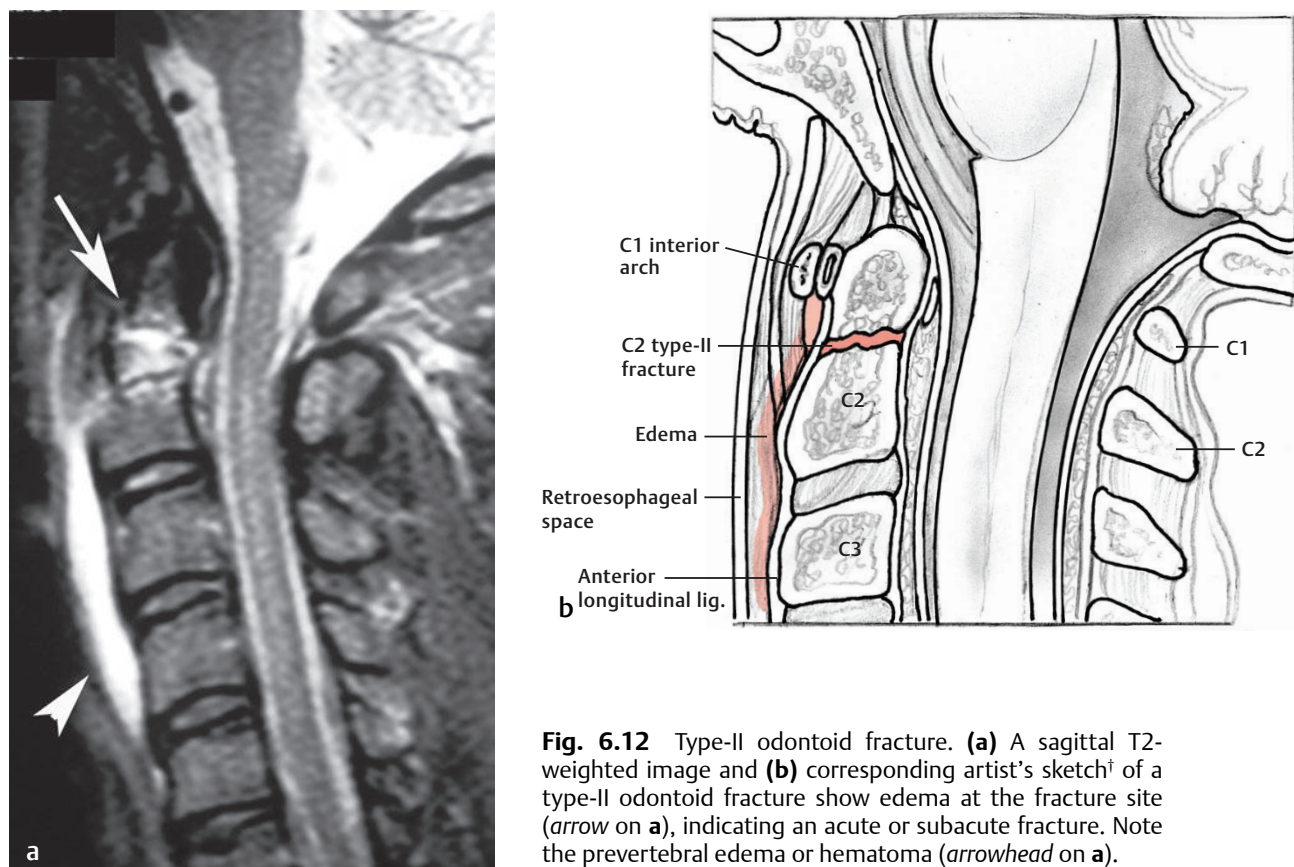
Type-II odontoid fracture. (a) A sagittal T2-weighted image and (b) corresponding artist's sketch† of a type-II odontoid fracture show edema at the fracture site (arrow on a), indicating an acute or subacute fracture. Note the prevertebral edema or hematoma (arrowhead on a).
